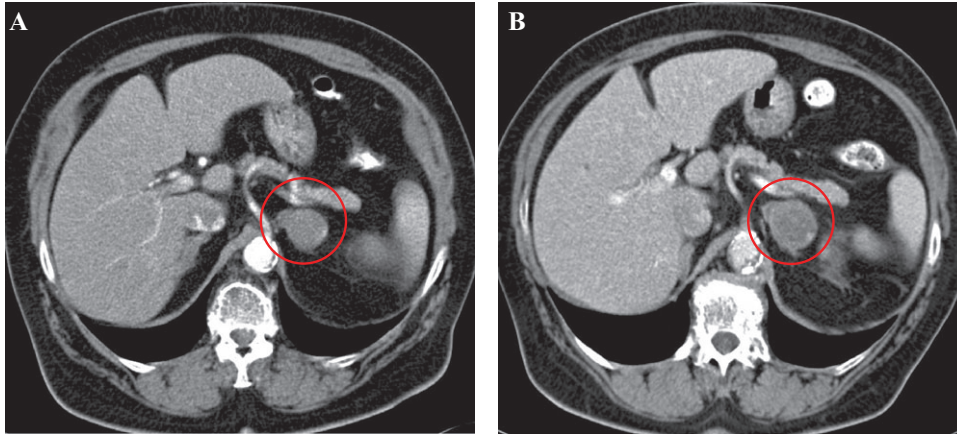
Abdominal CT scans showing growth of the left adrenal mass.
